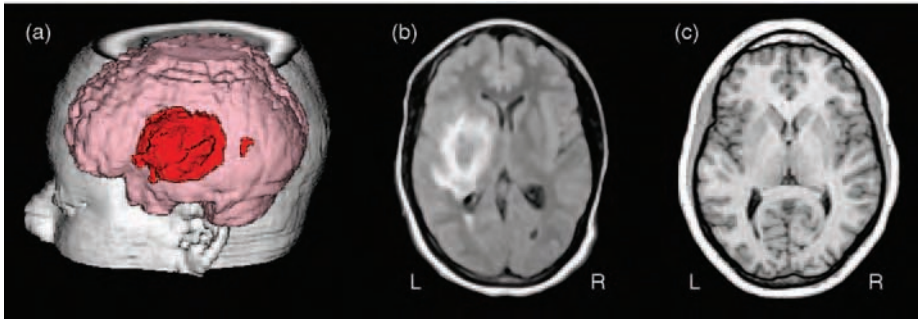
This child suffered what was thought to be a spontaneous rupture of an aneurysm involving the left middle cerebral artery. The magnetic resonance imaging (MRI) (middle panel) shows the extensive cerebrovascular accident (CVA) involving the central aspect of the left hemisphere, which when plotted in 3-D space is readily appreciated to be in traditional areas critical for language function. The right panel is an age-match normal control. Note the effacement of the ventricular system by the mass-effect of the lesion, displacing the ventricle. Note also the inflammatory reaction occurring outward from the central lesion site, where white matter in the occipital forceps is abnormal. This is distal disruption caused by the focal lesion.
